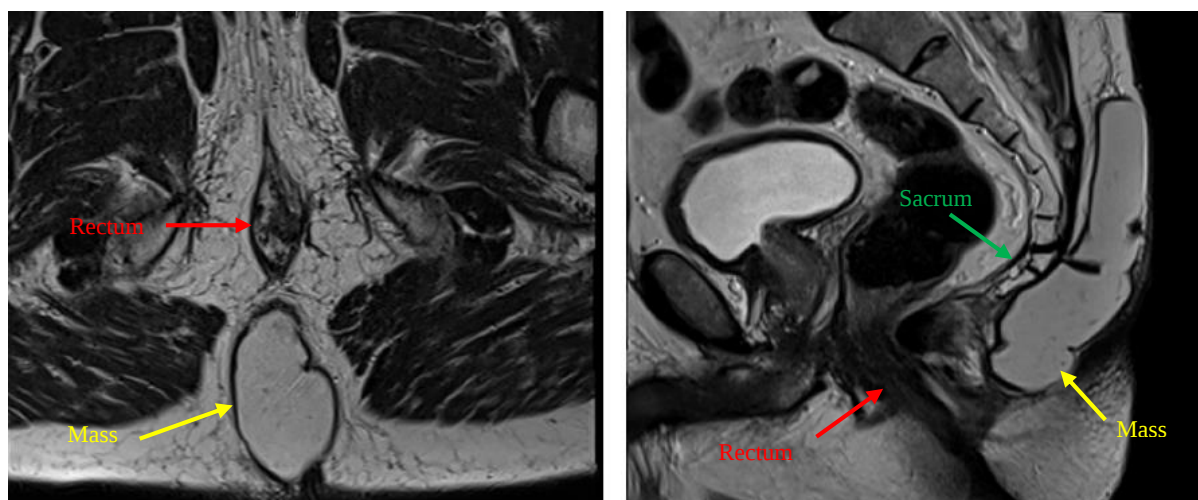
Magnetic resonance imaging (MRI) revealed a well-defined, ovoid cystic lesion measuring $120 \times 60 \times 25$ mm within the retrorectal/presacral space, located in the midline inferior to S3 level. On axial images, the lesion demonstrates homogeneous internal signal intensity with a thin, smooth, and regular wall. No definite solid component or internal nodular enhancement is identified. On sagittal images, the lesion appears as a large cystic structure with high T2 signal intensity, consistent with fluid content. It is closely related anteriorly to the rectum and posteriorly to the sacrum. Inferior extension toward the perineum is noted. No obvious invasion of adjacent structures is identified on the provided description.
